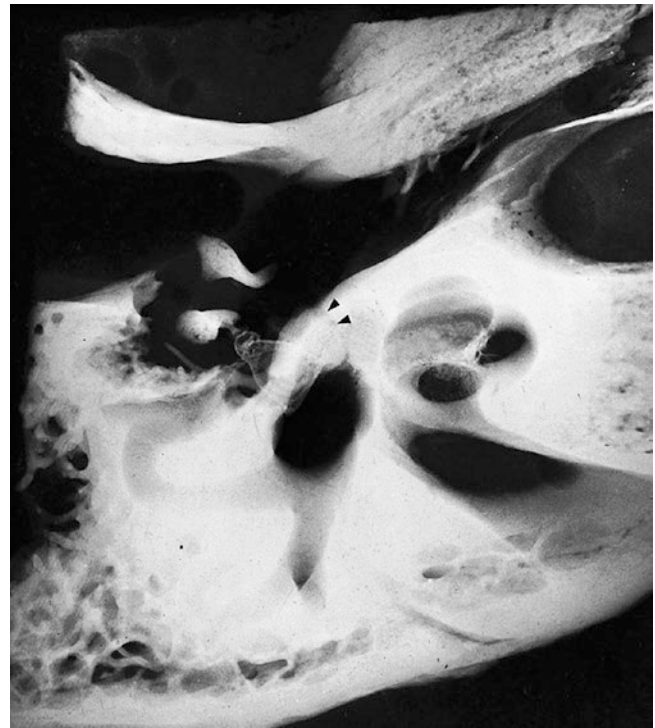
Radiograph of microslice of autopsy temporal bone with focus of otosclerosis. The focus is an area of mottled translucency in the region of the fissula ante fenestram, which is indicated by arrowheads
